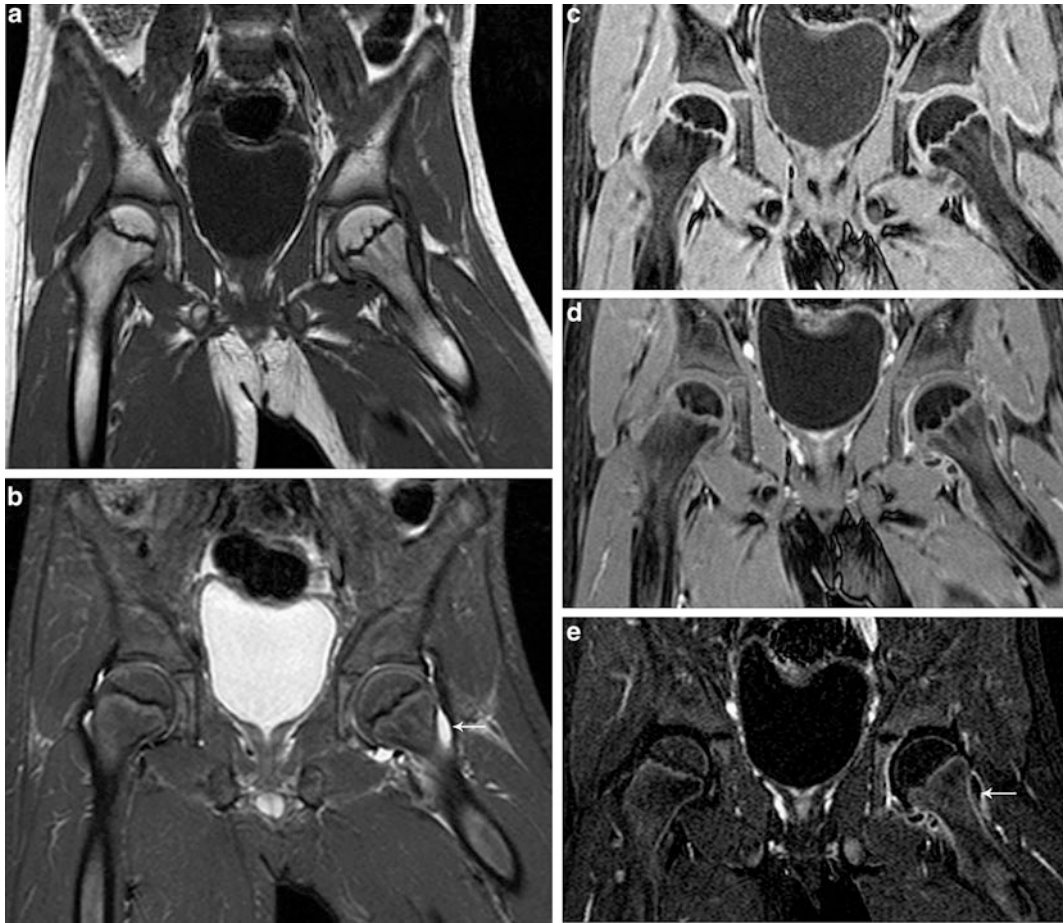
Seven-year-old boy with left hip pain. (a) Coronal T1-weighted image of the pelvis shows normal bone marrow signal with fatty SI of the capital epiphyses which are rounded. (b) Coronal water-sensitive image shows a small left hip effusion (*arrow*) with normal
